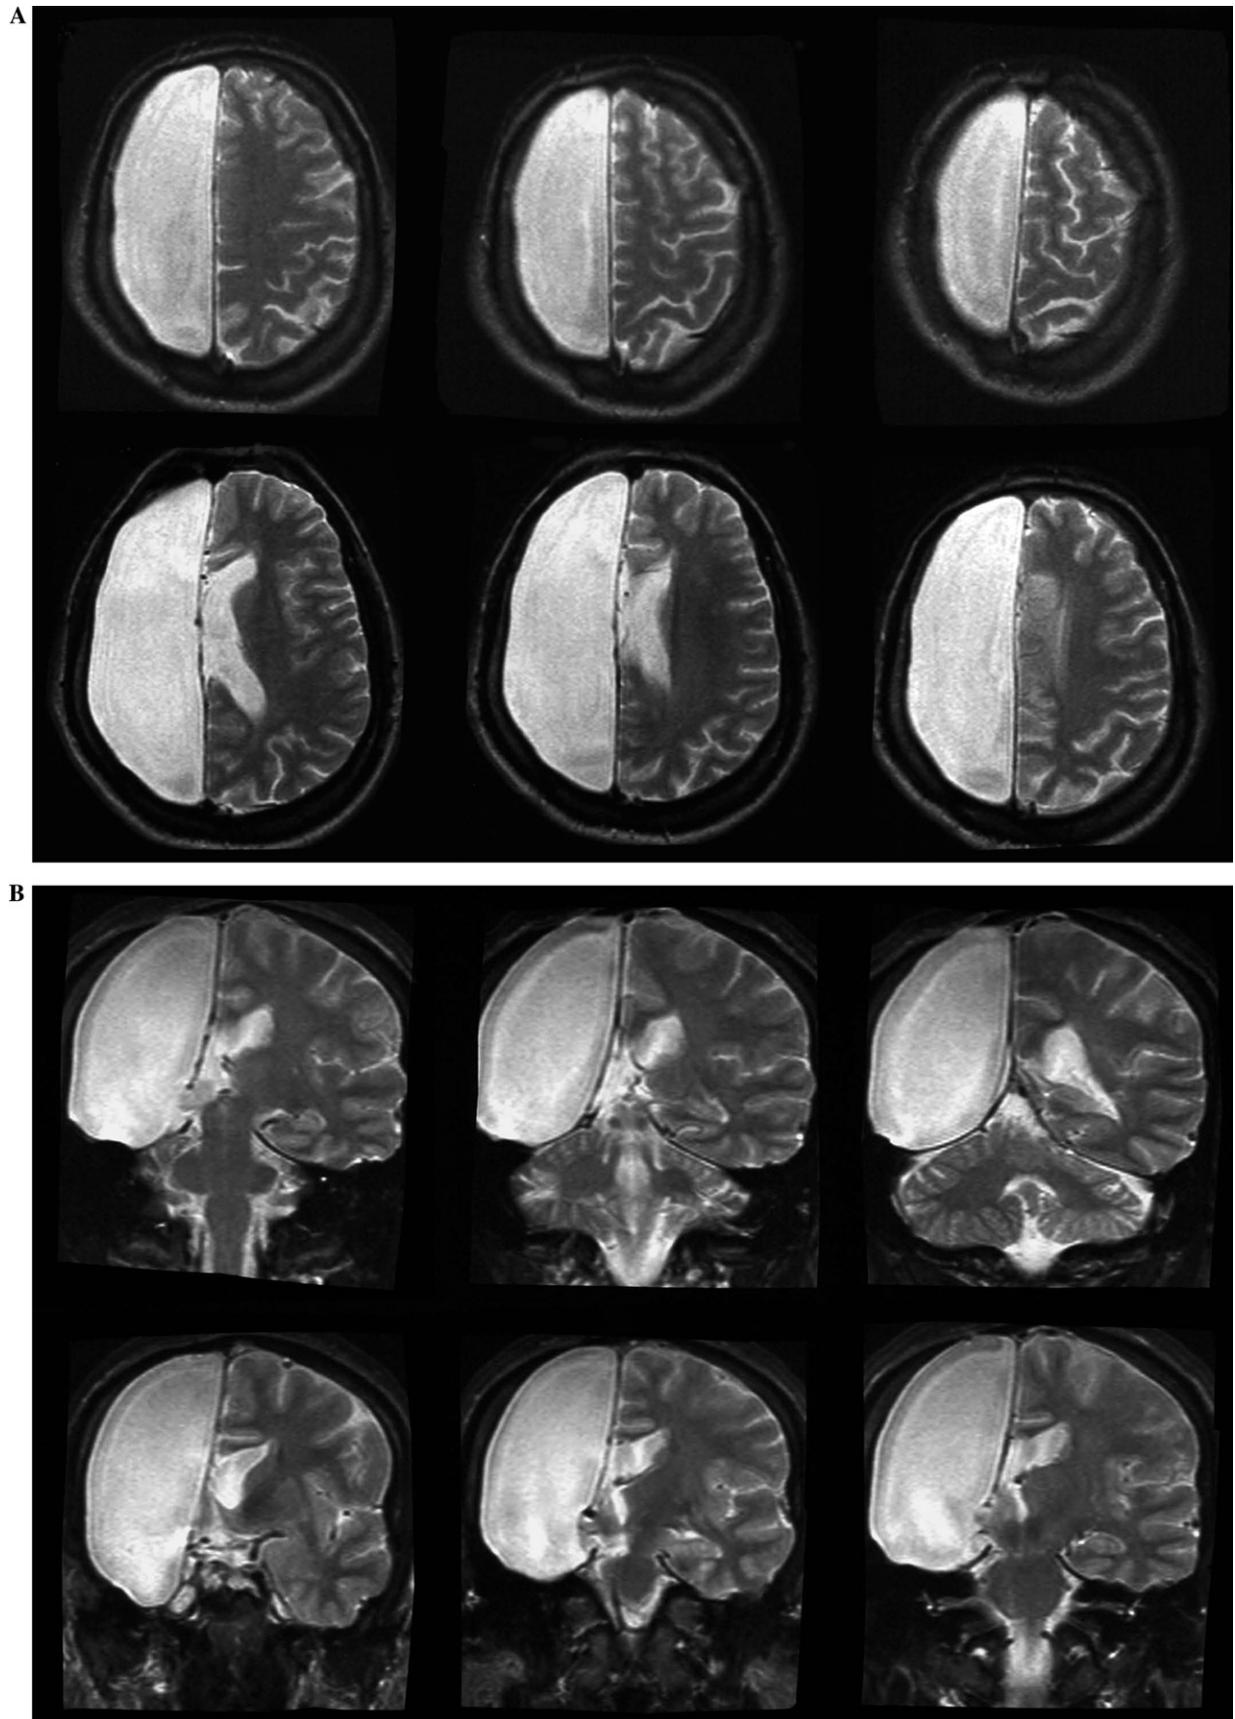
(A) MRI scan of BL: axial view. (B) MRI scan of BL: coronal view.
